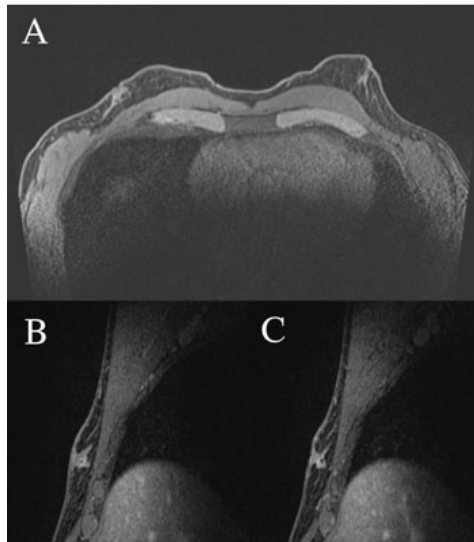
Bilateral breast diagnostic magnetic resonance imaging. (A) Axial view. (B) Right breast sagittal view. (C) Left breast sagittal view.
